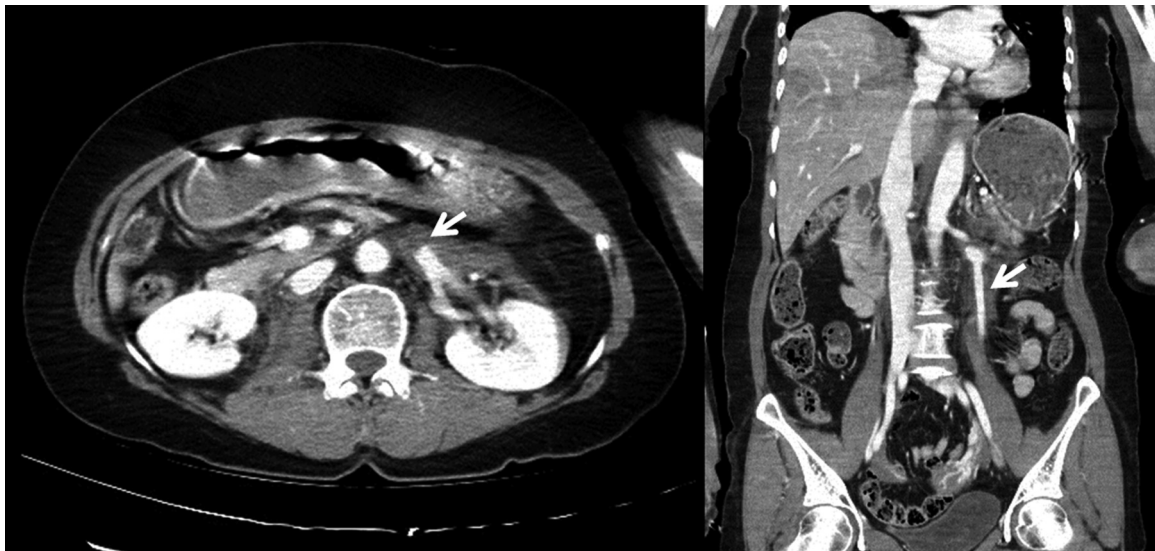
Initial CT scan, showing that the left renal vein was occluded by an adjacent hematoma and the left ovarian vein was patent.
